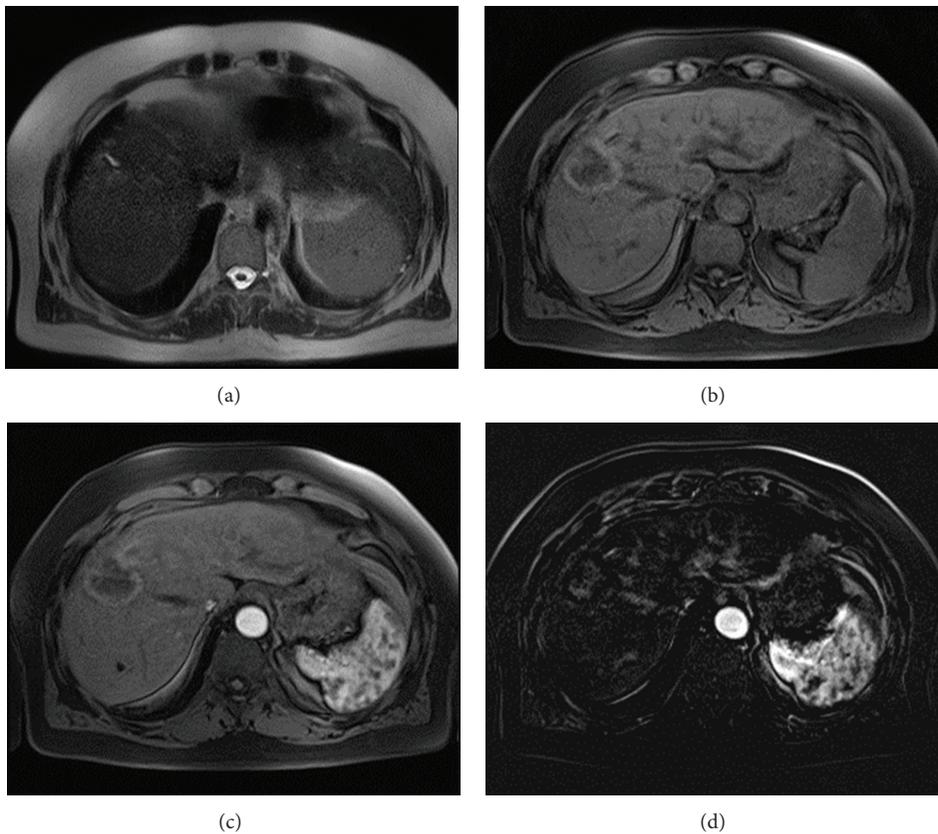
69-year-old woman treated with RFA for HCC. (a) Axial Haste T2-W, at 1-month followup; treated necrotic nodule, heterogeneously isointense to hypointense. A dilatation of an intrahepatic biliary branch, as a complication of RFA, is recognizable. (b) Axial Vibe T1-w FS, at 1 month followup: treated necrotic nodule, heterogeneously isointense to hyperintense, with peripheral hypointense rim. (c) At 1-month followup arterial-phase scan MR image showing no contrast enhancement. (d) At 1-month followup postprocessing subtract image (arterial phase and no contrast phase) showing no contrast enhancement.
